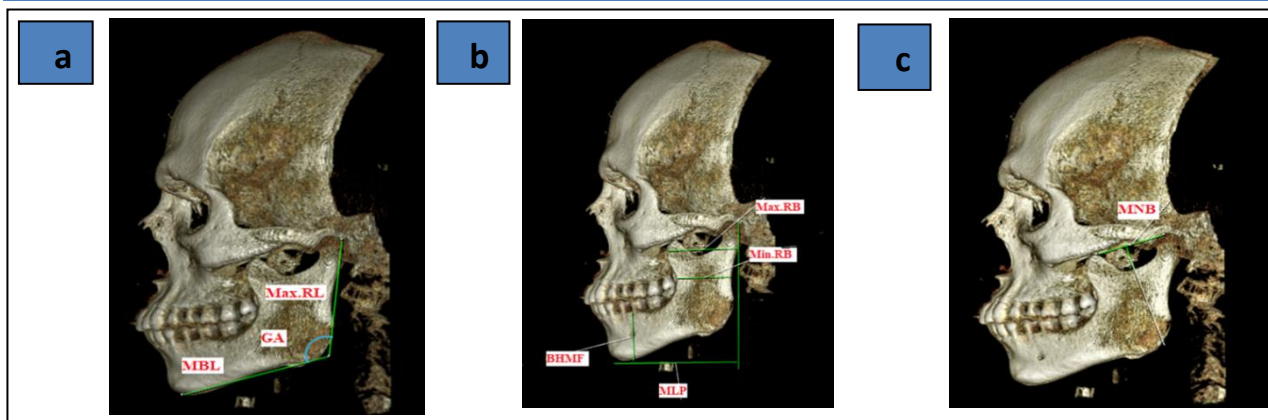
Lateral view full skull CBCT, a: Max. RL, maximum ramus length; GA, gonial angle; MBL: mandibular base length. b: Max. RB, maximum ramus breadth; Min. RB, minimum ramus breadth; MLP, mandibular length projection; BHMF, body height at mental foramen. c: MNB, mandibular notch breadth.
